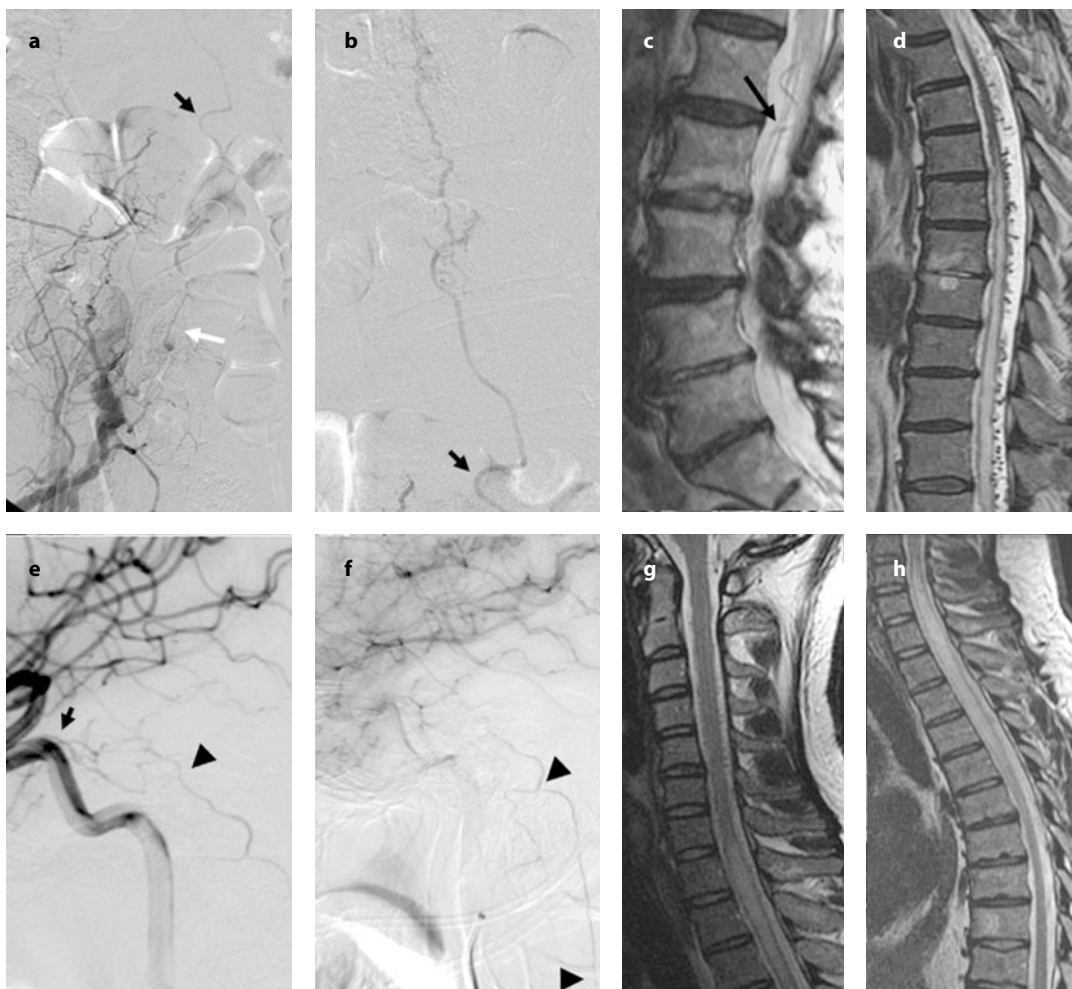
Atypical dural arteriovenous fistulas. These cases highlight the importance of complete angiographic evaluation that should be done from the cranium to the sacrum. a–d: A 73-year-old patient. Dural arteriovenous fistula (type I) supported by tiny arteries arising from the left hypogastric artery. The feeder pierces the dura at the S2 level and communicates with the sacral epidural veins (*white arrow*). The spinal venous drainage (*black arrow*) runs along the cauda and reaches the conus medullaris at the L1 level. MRI shows congestive myelopathy of the conus medullaris with perimedullary dilated veins. e–h: A 42-year-old patient with progressive neurological impairment. Selective angiography shows a type-V Cognard intracranial dural arteriovenous fistula fed by the meningo-hypophyseal trunk of the left internal carotid artery (*black arrow*). The fistula drains into the petrous and spinal perimedullary veins (*black arrowheads*). There are no feeders from the external carotid and vertebral branches or from the radiculomedullary arteries. MRI shows congestive myelopathy of the upper thoracic segment (from C7 to T6) with perimedullary dilated veins
